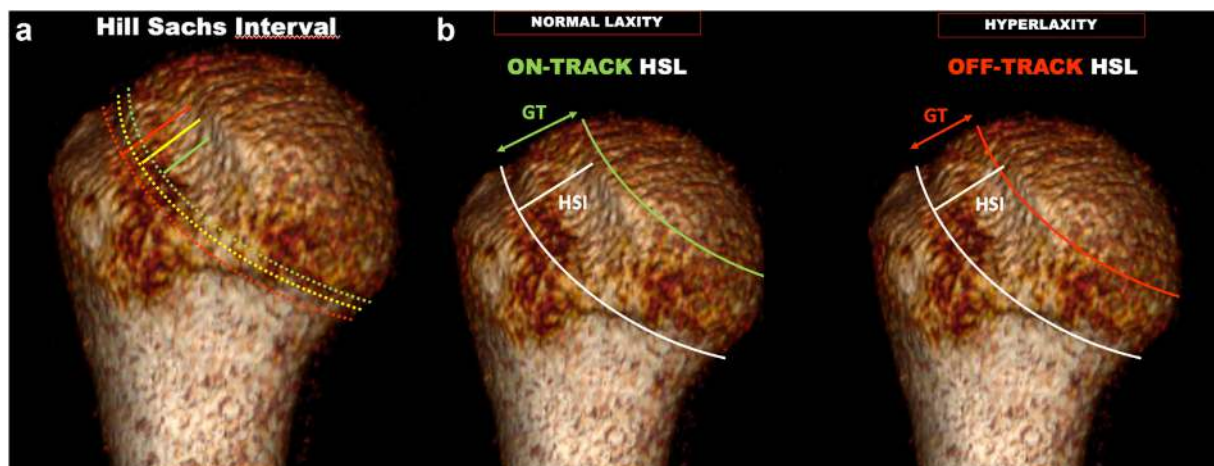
a) Computed tomography scan of a Hill Sachs lesion (HSL) with unclear determination of the exact Hill-Sachs Interval (HSI: distance between cuff insertion and medial border of Hill-Sachs lesion) due to the difficulty in identifying the cuff insertion. b) The glenoid track (GT) of a patient will change based on its laxity as the 83 % reported in the literature is not a constant but rather determined by how much the glenoid can overlap with the cuff insertion. Thus an on-track Hill Sachs lesion (HSI is smaller than GT) can become off-track (HSI is greater than GT) if the patient is hyperlax. HSL = Hill Sachs lesion, HSI = Hill Sachs interval, GT = glenoid track.
